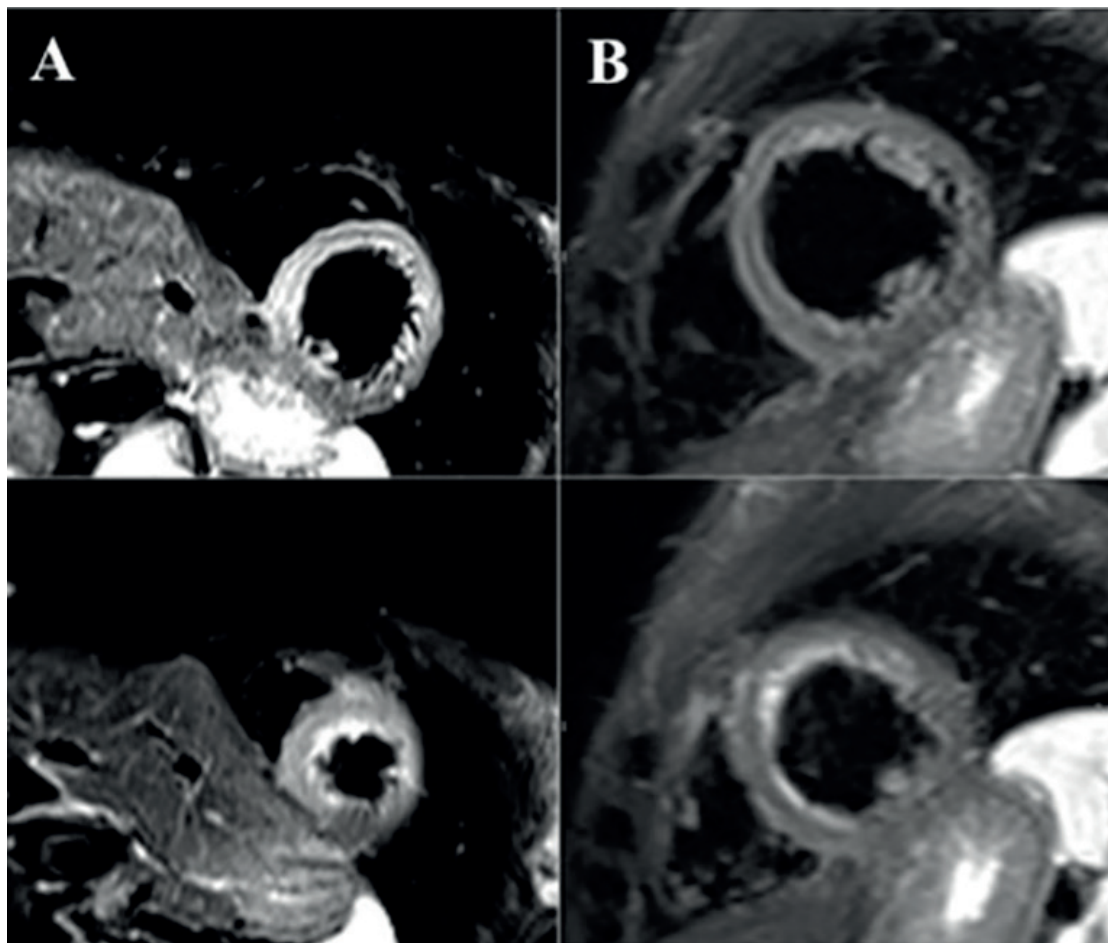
Magnetic Resonance Imaging. A, Short axis, T2-weighted images show a diffuse edematous involvement of the mid-ventricular and apical segments. B, After 1 month T2-weighted images show the absence of edema.
